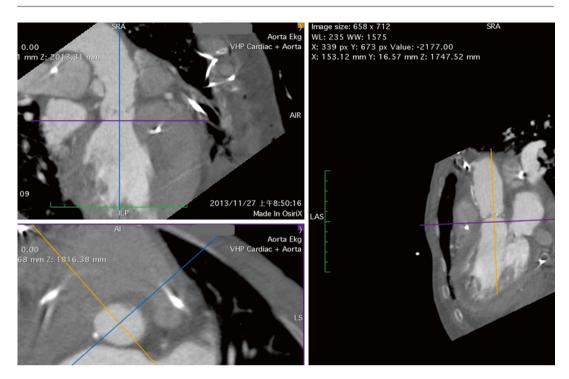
CT angiogram showed the anatomical relationship between aortic annulus and its surroundings
